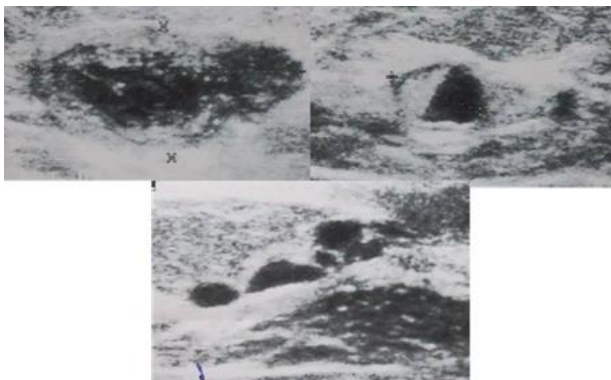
Ultrasound images of multiple and different masses
